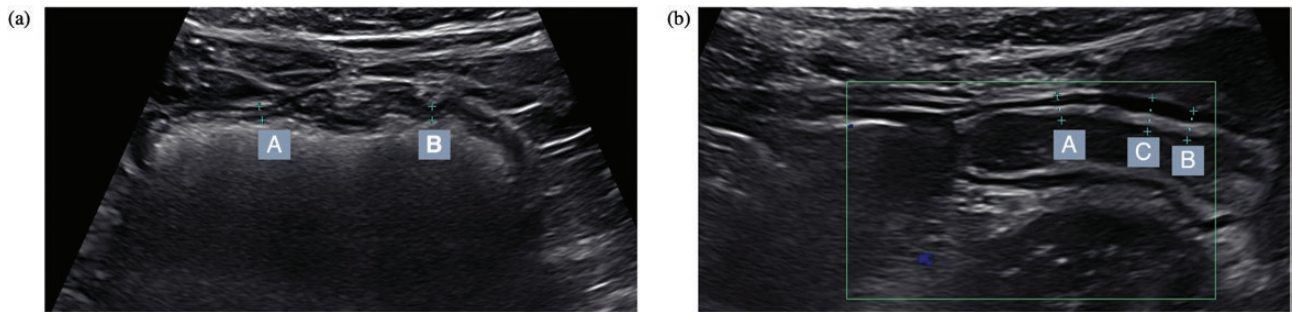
Intestinal ultrasound images comparing patients with inflammatory bowel disease using the Canon i700 machine. (A) Normal sigmoid colon from Crohn's disease patient in remission with mucosal measurements denoted at points along the sigmoid colon with line A measuring 0.2 cm and B measuring 0.3 cm. (B) Inflamed sigmoid in a Crohn's patient with mucosal measurements A, B, and C measuring 0.25 cm, 0.3 cm, and 0.34 cm, respectively. Mural stratification is intact.
